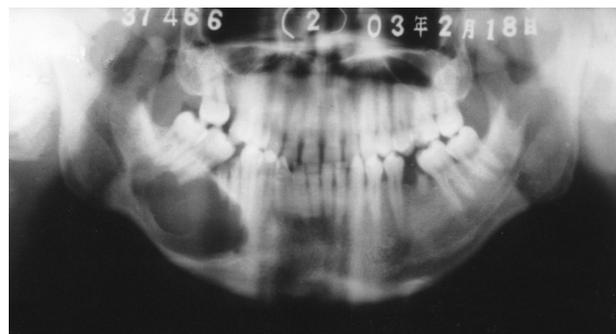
Panoramic radiograph showing unilocular well-circumscribed radiolucency extending from tooth 43 to 47, with resorption of root apices of 44 to 47 and displacement of 46.
